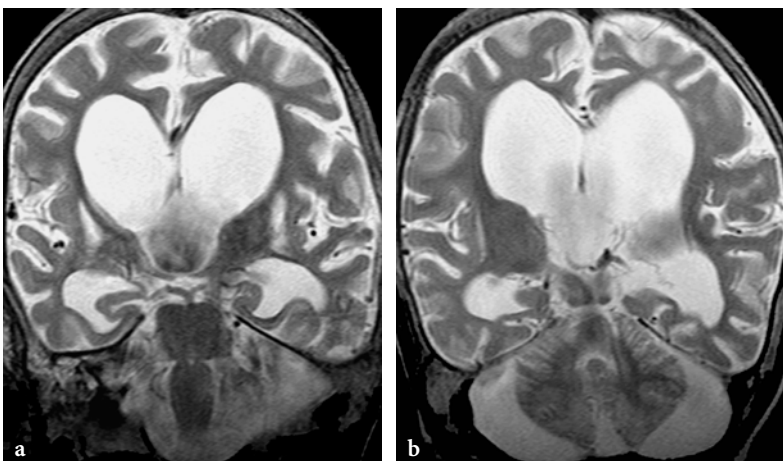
Coronal T2-weighted fast spin-echo MR images in a 7-year-old female patient with 3-methylglutaconic aciduria in the chronic phase of the disease. a The basal ganglia are atrophic and markedly hyperintense. Very marked enlargement of the extra and in particular of the intracerebral CSF spaces, characterizing diffuse brain atrophy. b Very prominent atrophy of the cerebellum
